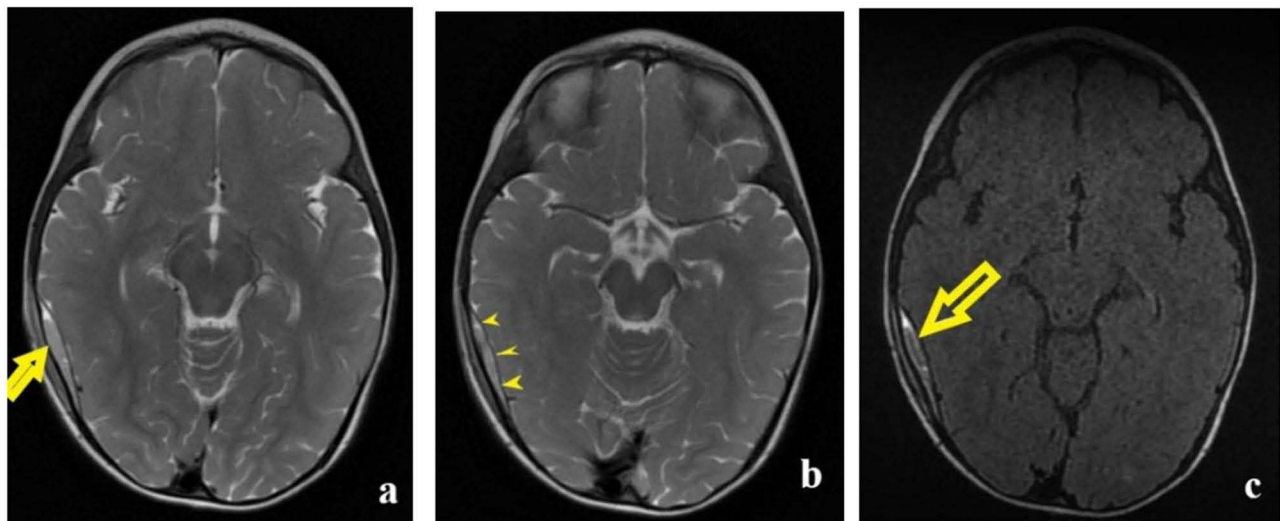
(a) The T2-WI axial section depicts a right temporoparietal lenticular collection (yellow arrow) with a small mass effect on the underlying brain parenchyma. (b) T2-WI axial section: yellow arrowheads point to the dura mater that appears as a fine black line between the hematoma and the brain parenchyma. (c) FLAIR axial imaging shows the same collection with a hyperintense signal (yellow arrow).
